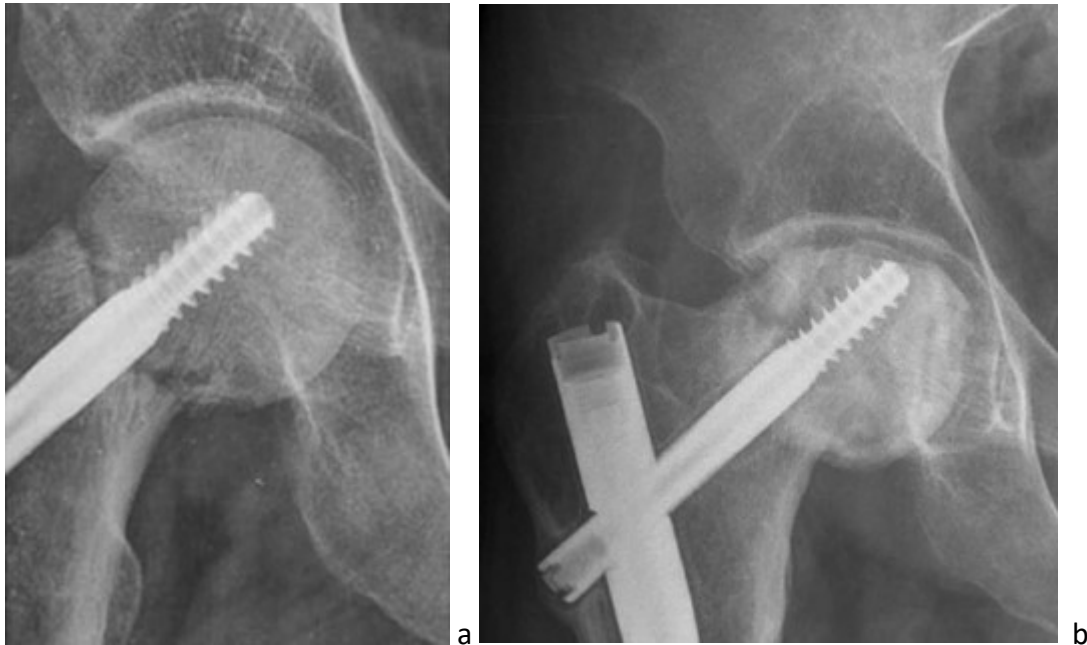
Radiographs of non-union (a) and avascular necrosis of the femoral head (b) in patients with femoral neck fractures. Note the fracture line that remains in the case of non-union, and the collapse of the femoral head in the avascular necrosis case. Images reproduced with permission (email correspondence)[56].
